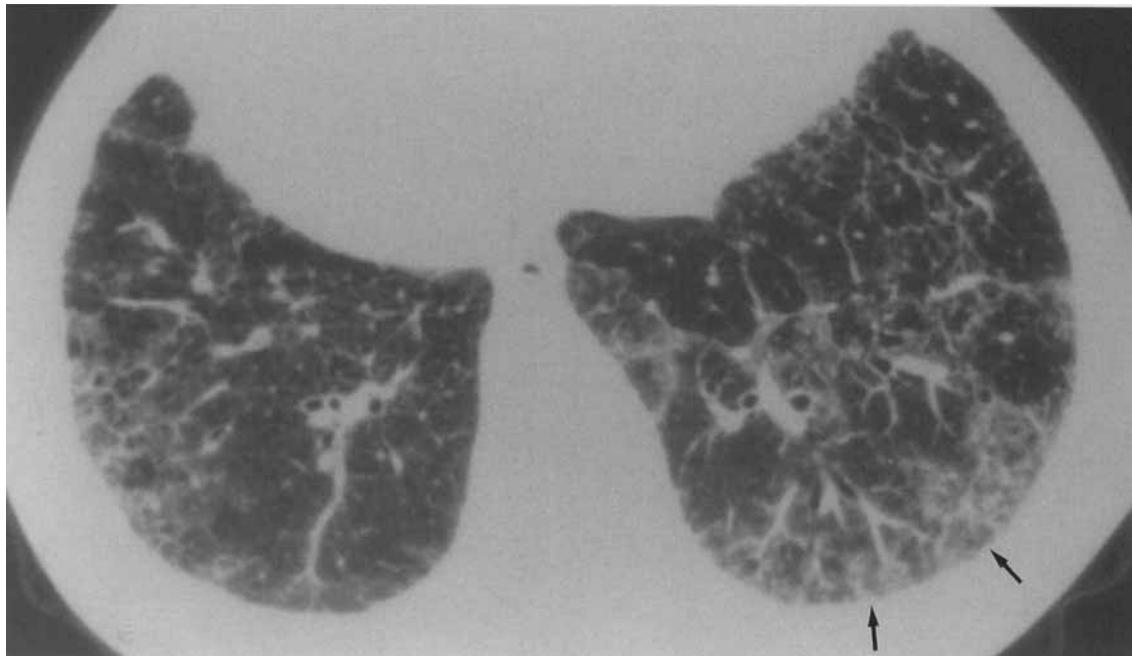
HRCT scan in a neoplastic patient treated with bleomycin, in prone position, showing a diffuse alteration of pleuro-parenchymal interfaces and fibrotic changes, mostly localized in the area of the lower posterior left lung (arrows).
